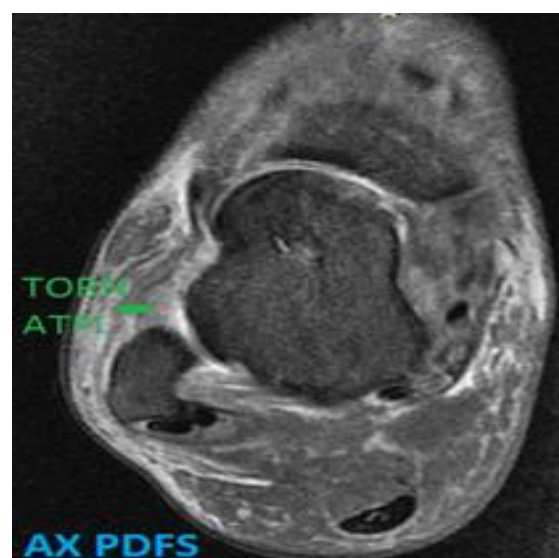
Axial PDFS MRI Showing Non Visualisation of ATFL, Suggestive of-Torn ATFL
